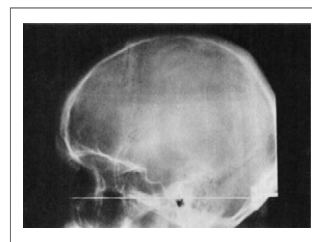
Lateral skull radiograph of normal, adult human subject showing position (horizontal, radio-opaque line) of lowest of seven PET slices depicted in Fig. 5. Slices are separated by 14 mm (center to center). Radio-opaque wire is 1 mm in diameter.
